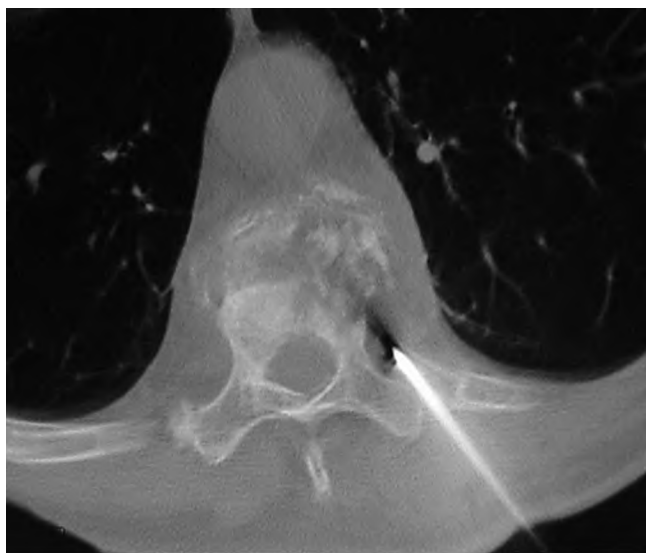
CT-guided biopsy of destruction of vertebral body T10.
